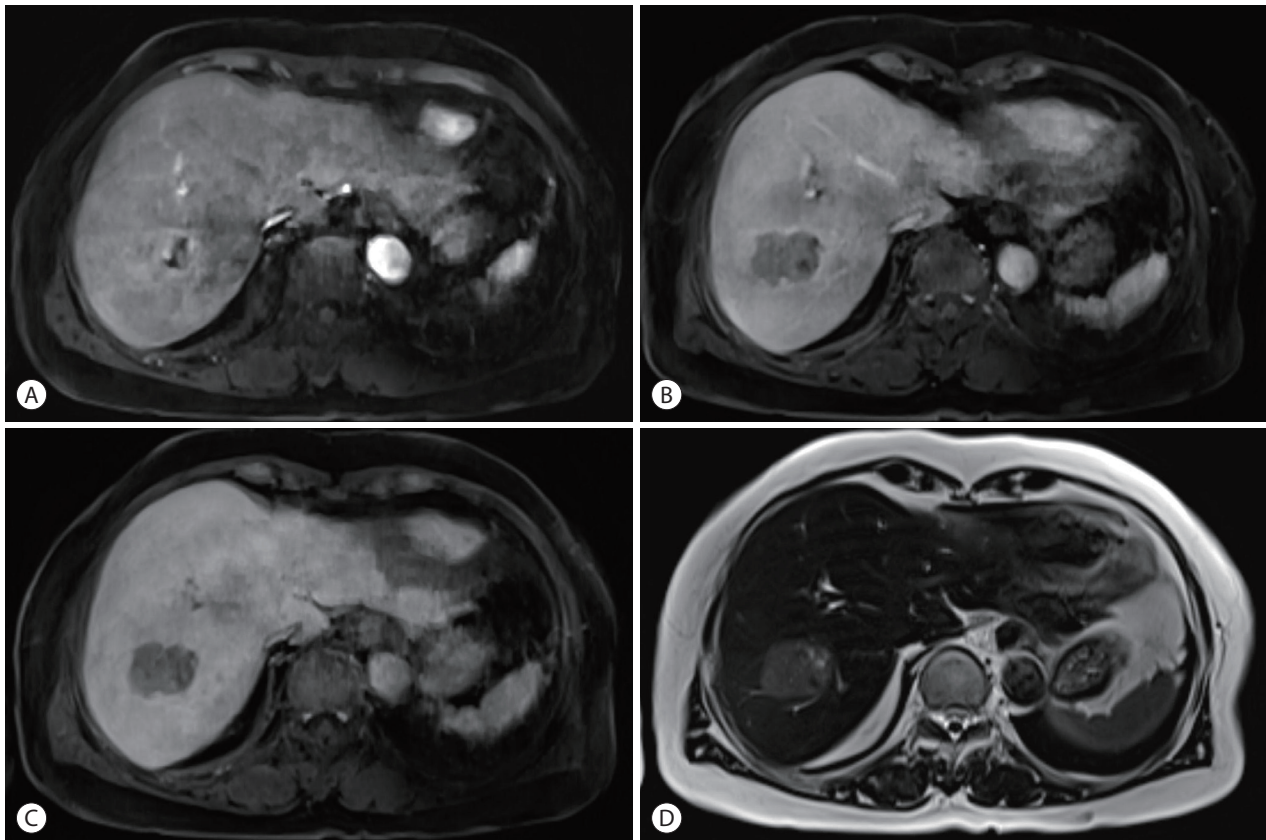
Dynamic liver magnetic resonance imaging findings. The mass is enhanced heterogeneously and also shows peripheral rim enhancement in the arterial phase (A). Wash-out in portal phase (B). Hypointensity in hepato-biliary phase (C). In T2-weighted images, it presents moderate hyperintensity (D).
